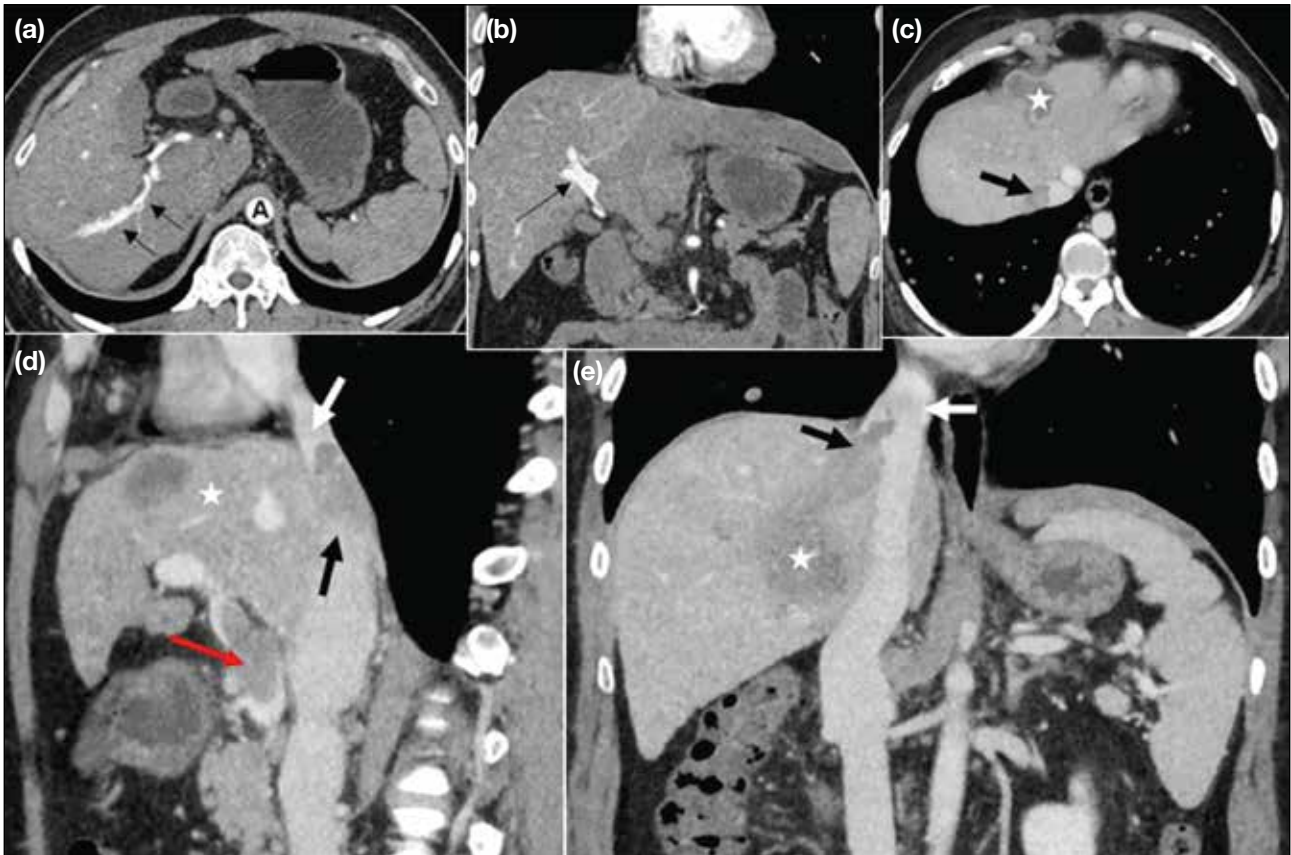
Hepatocellular carcinoma (HCC) in a 56-year-old man. (a) Axial and (b) coronal contrast-enhanced computed tomography (CECT) images in the early arterial phase show contrast opacification of the aorta (A), hepatic artery, and portal vein due to an arteriportal fistula in the right lobe of the liver (black arrows). (c) Axial CECT image shows HCC (star) with thrombus in the inferior vena cava (IVC) [black arrow]. (d, e) Coronal CECT images in the venous phase show HCC (stars), along with thrombus in the portal vein (red arrow in [d]) and hepatic veins (black arrows) extending into the IVC (white arrows).
